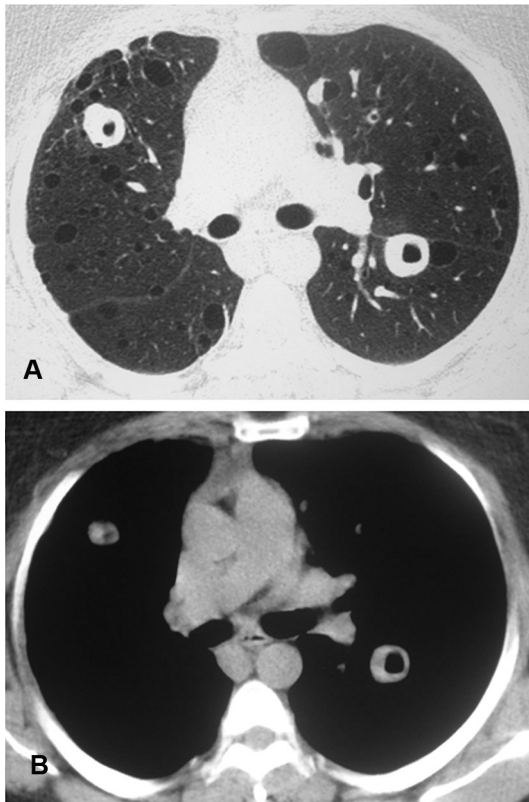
A 52-year-old woman with Sjögren syndrome. Axial CT images with lung (a) and mediastinal (b) window settings showed sparse pulmonary cysts, compatible with lymphocytic interstitial pneumonia. Nodules, most cavitated, are also present. Note in (a) the presence of a nodule abutting the cyst wall on the lingula. Lung biopsy confirmed the diagnosis of amyloidosis
